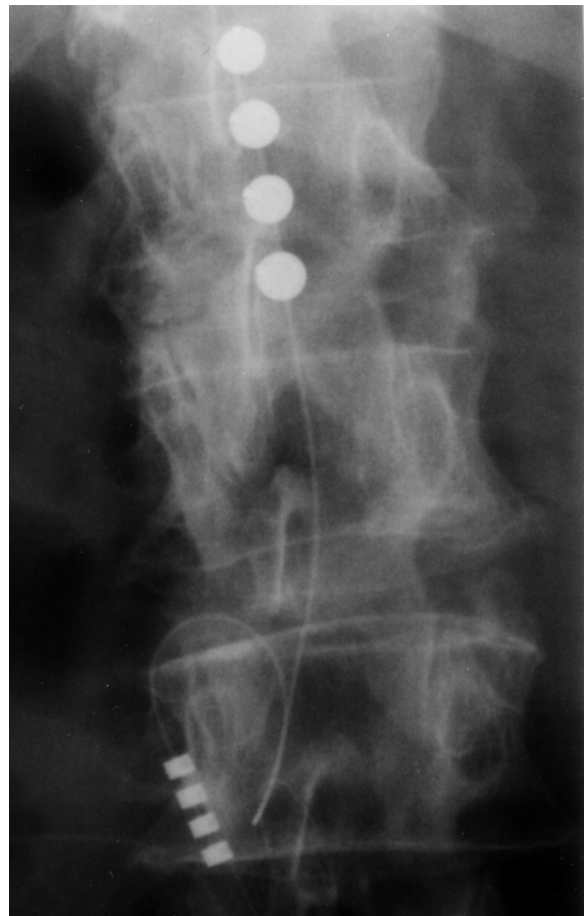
X-rays showing positioning of a spinal stimulating paddle (laminotomy).
